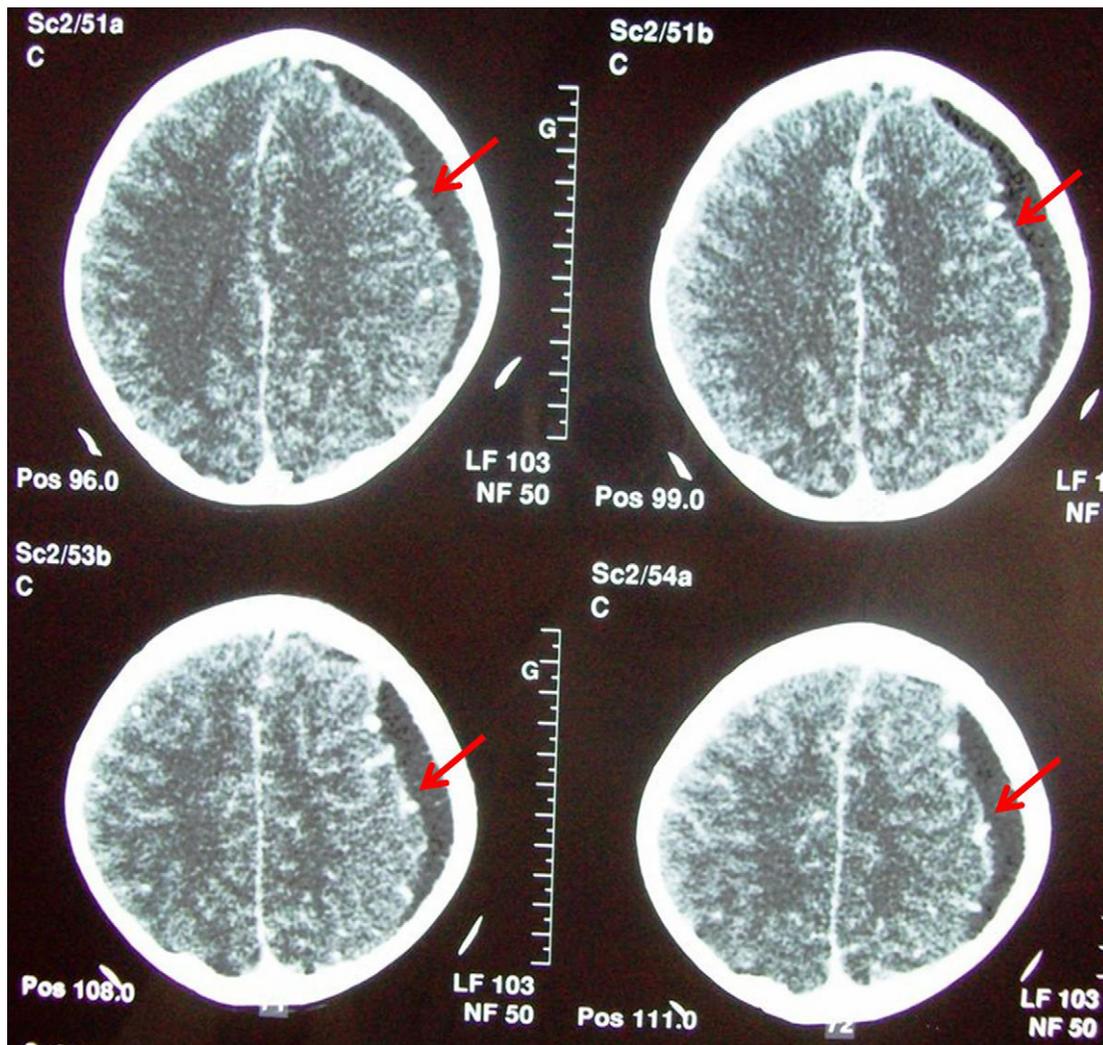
CT scan performed on the day of admission showing a left hemispheric subdural empyema. CT = computed tomography.
